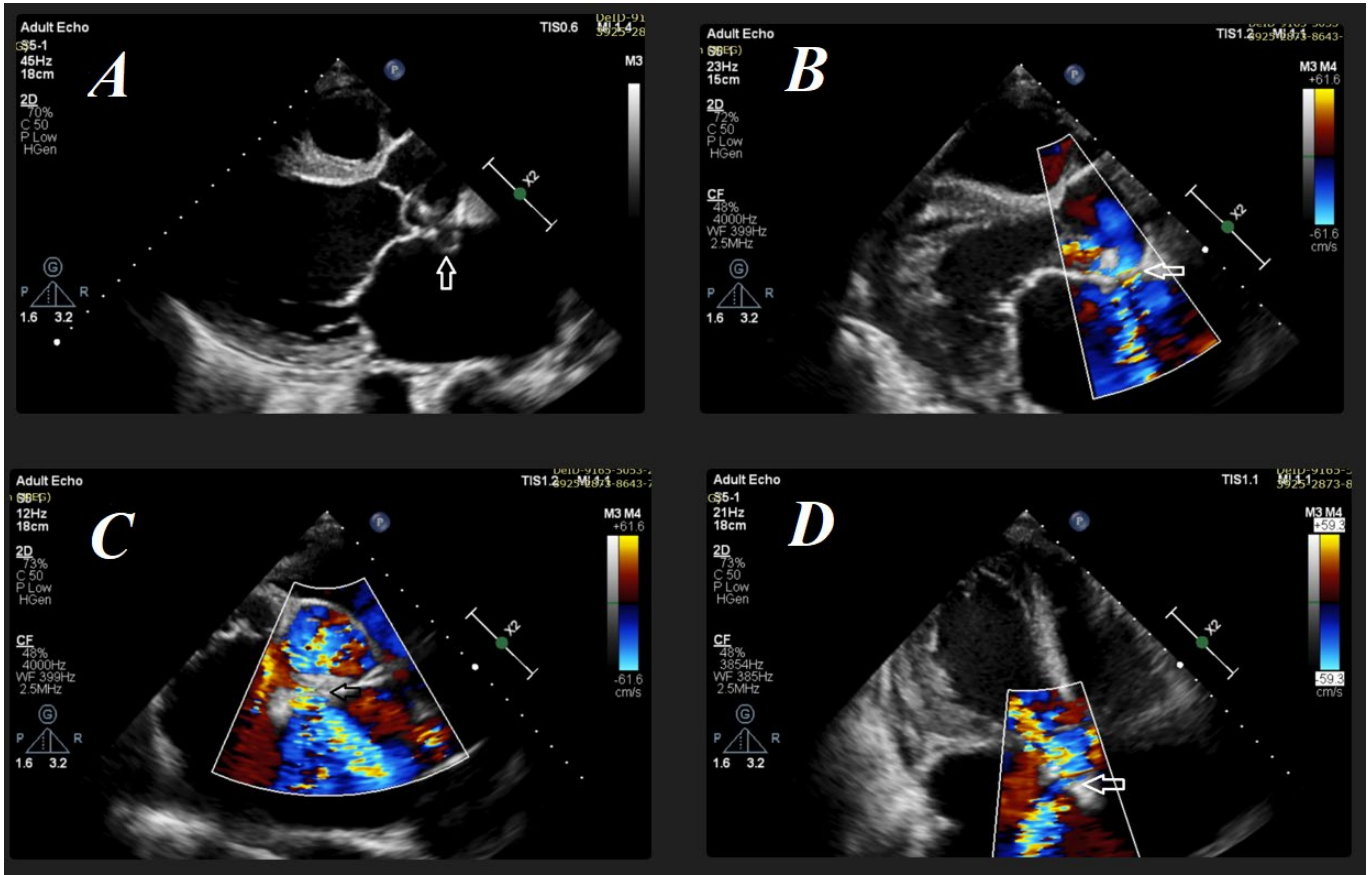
(A) Echocardiography revealing sinus of Valsalva dilation and irregularity of the sinus of Valsalva wall in the parasternal long axis view. The arrow indicates the site of the ruptured sinus of Valsalva aneurysm (SVA). (B, C, D) Echocardiography with color Doppler demonstrating a high-velocity aliasing mosaic of blood flow from the non-coronary sinus (NCS) to the left atrium (LA). The arrow indicates the color flow from the ruptured SVA to the LA.
